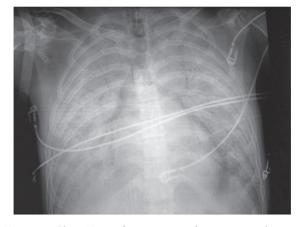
Chest X-ray after initiation of extracorporeal membrane oxygenation: Bilateral patchy alveolar consolidations and spontaneous pneumomediastinum.
